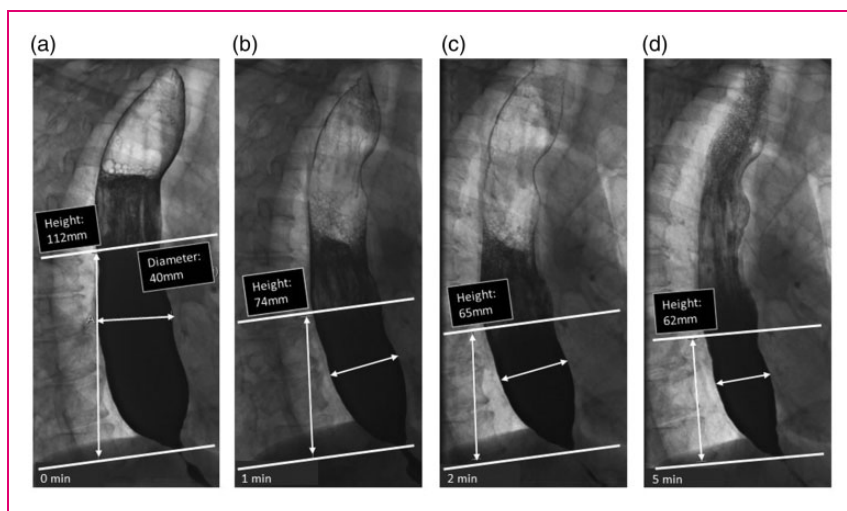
Interpretation of timed barium esophagram. Radiographs taken 0, 1, 2 and 5 minutes in left posterior oblique position after ingestion of 100 to 200 mL low-density barium suspension in an achalasia patient. Measurement of height and width of barium column, measured from the OGJ to the barium-foam interface. Barium height of >5 cm at 1 min and >2 cm at 5 min are suggestive of achalasia.
